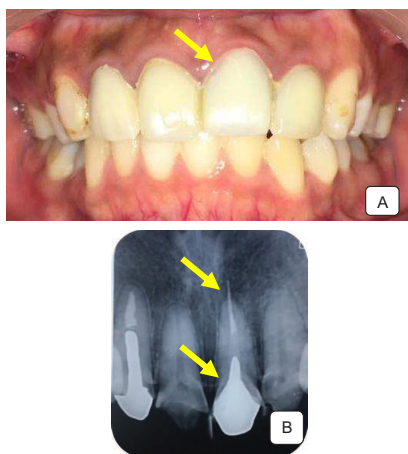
A. Clinical dentition photograph showed acrylic crown on left maxillary central incisor that was poorly adapted and contoured, B. Radiographic photograph showed overfilled obturation material, periapical lesion, and post on two third of coronal root canal.
